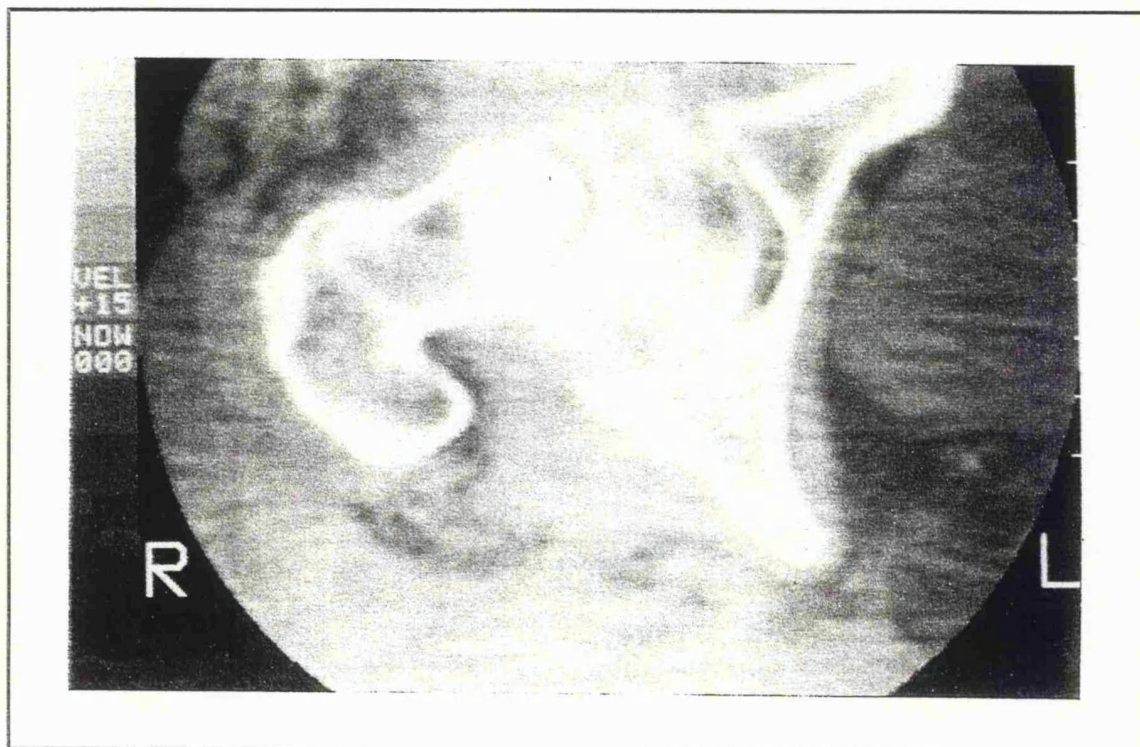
A CT scan showing both anterior and posterior comminution.
